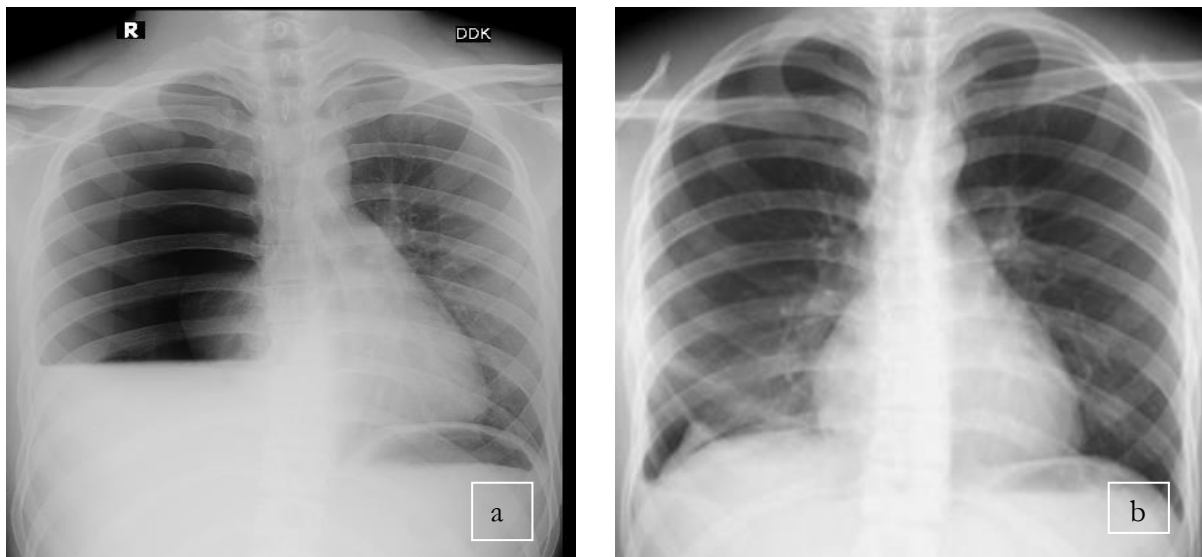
Follow-up Chest X-ray; a) Entered the emergency room, and b) after WSD revocation
